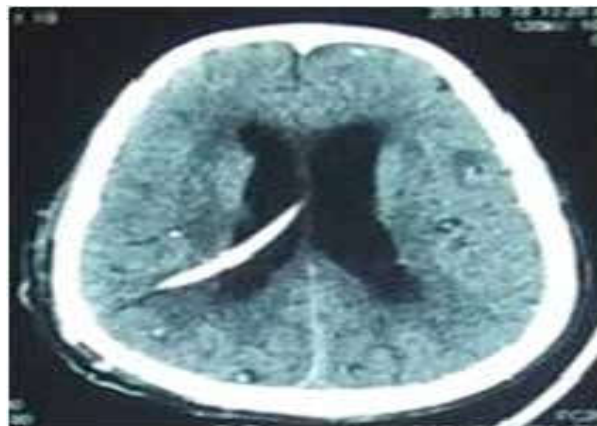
Post op CT Brain after right VP shunt insertion
